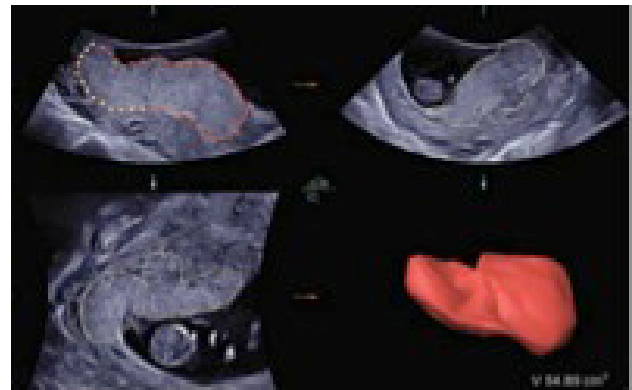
Placental volume by 3D ultrasound in the first trimester of pregnancy.
